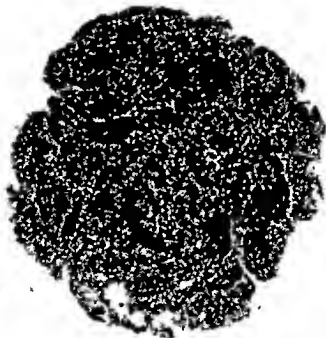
Roentgenogram of the calcified placenta of Figure 511, lying flat on the film
